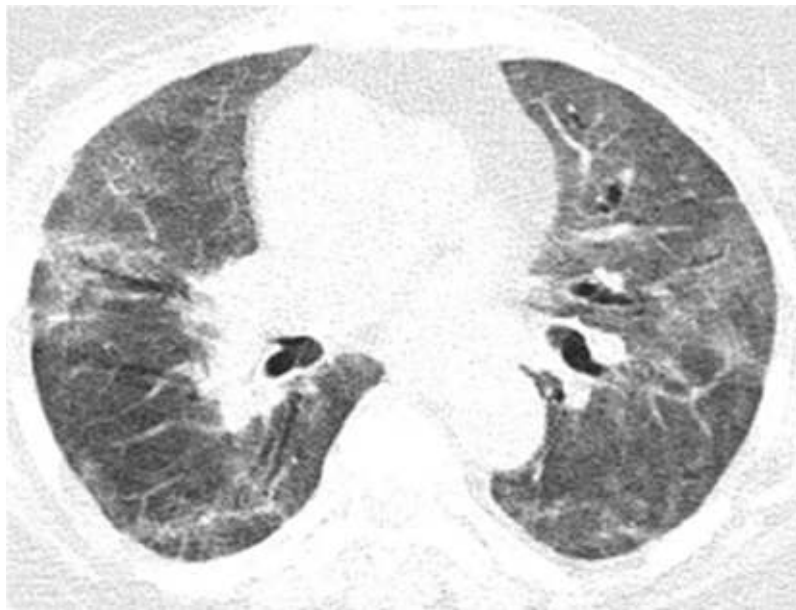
After 10 days, the thoraco-pulmonary CT of the Case 10 patient revealed that the previously described lesions are numerically and dimensionally stationary, at times reduced in intensity. In conclusion, pulmonary lesions of SARS-CoV-2 type in discrete remission, and were severely impaired.
